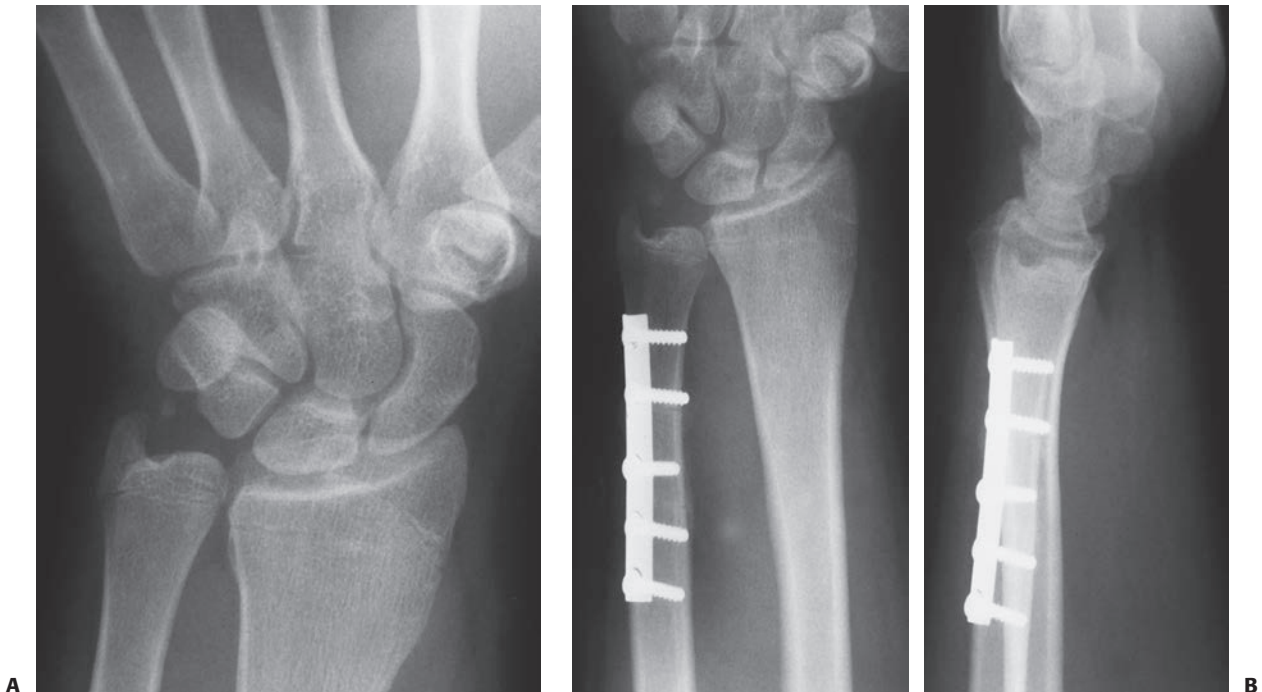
A: AP radiograph of distal radial growth arrest, ulnar overgrowth, and an ulnar styloid nonunion. Wrist arthroscopy revealed an intact triangular fibrocartilage complex. B: AP and lateral radiographs after ulnar shortening osteotomy.
